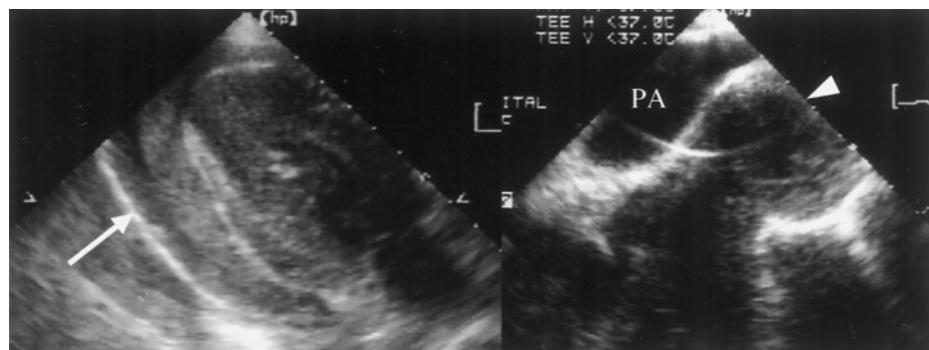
Echocardiography showing (A) pericardial effusion and (B) an aortic aneurysm protruding into the pericardial cavity to the left of the pulmonary artery.
